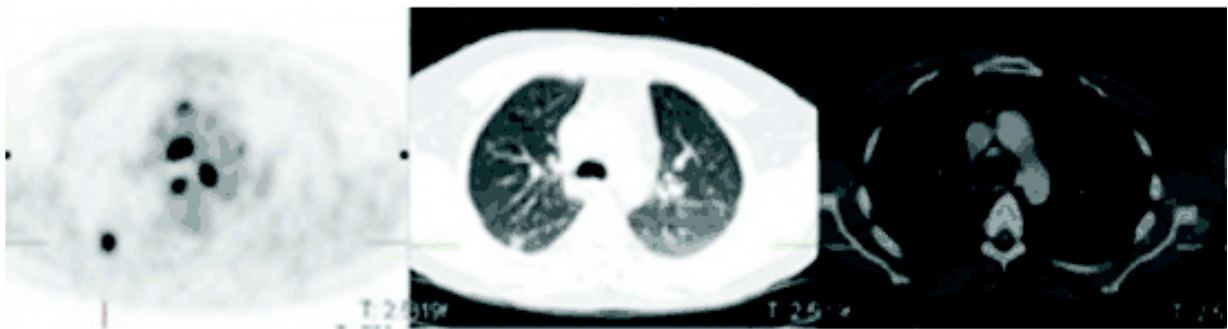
F-18-FDG Mediastinal LNs: Anterior SUVmax 8.44, Middle SUVmax 14.47, and Posterior SUVmax 16.0
